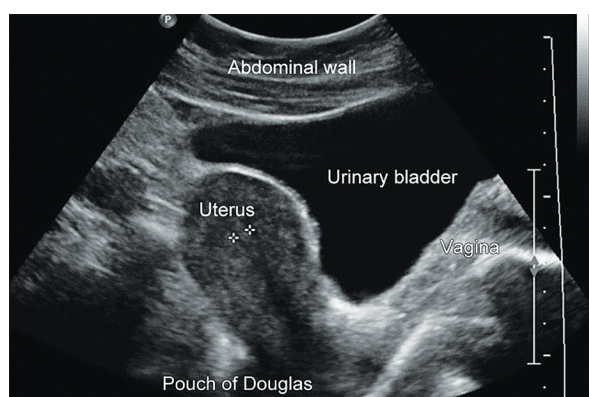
Typical Transabdominal Ultrasound Findings of a 17-Year-Old Female's Uterus: A Pear-Shaped Uterus after Puberty, with the Uterine Fundus Exhibiting Greater Growth in Comparison to the Cervix [12].
